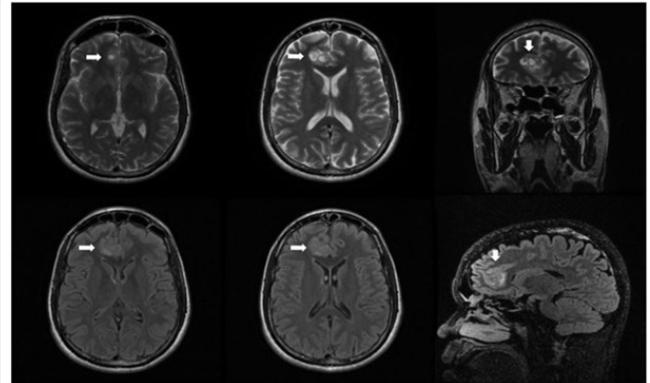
MRI T2-weighted images (upper images) and FLAIR sequences (lower images), depicting a 2.5 cm hypersignal expansive formation (arrow) centered on the cingulate cortex. This is a confirmed case of neurocryptococcoma in immunocompetent patient.
